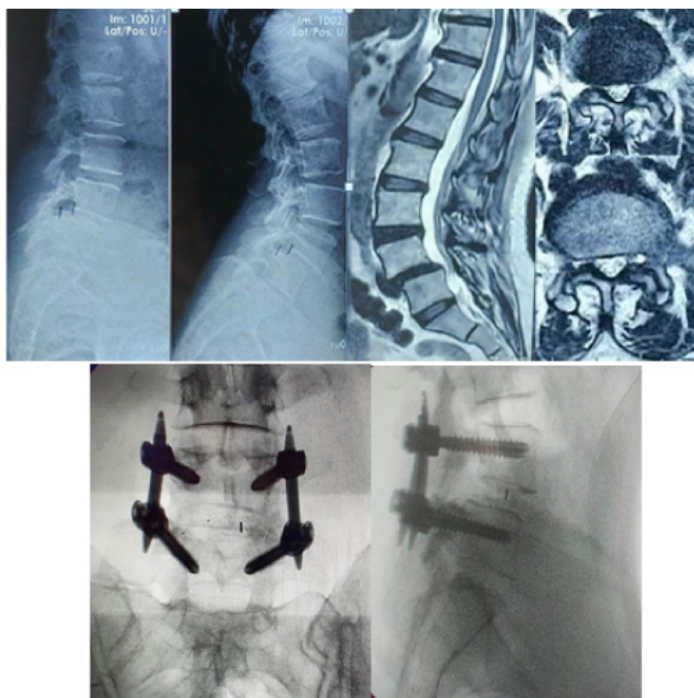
Hypertrophied facets- X-ray and MRI, Intra-op imaging post-transforaminal lumbar interbody fusion
